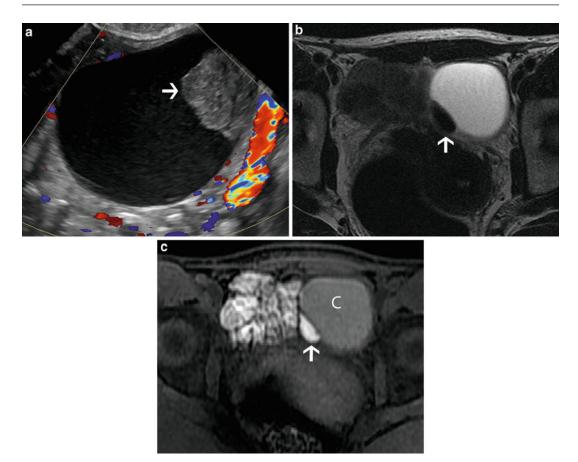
A 44-year-old woman with pelvic pain. Transvaginal color Doppler US (a) shows an ovarian cyst with an intracystic solid component (*arrow*) that could represent clot or soft tissue. The solid component (*arrow*) is hypointense on axial T2-weighted MR image
